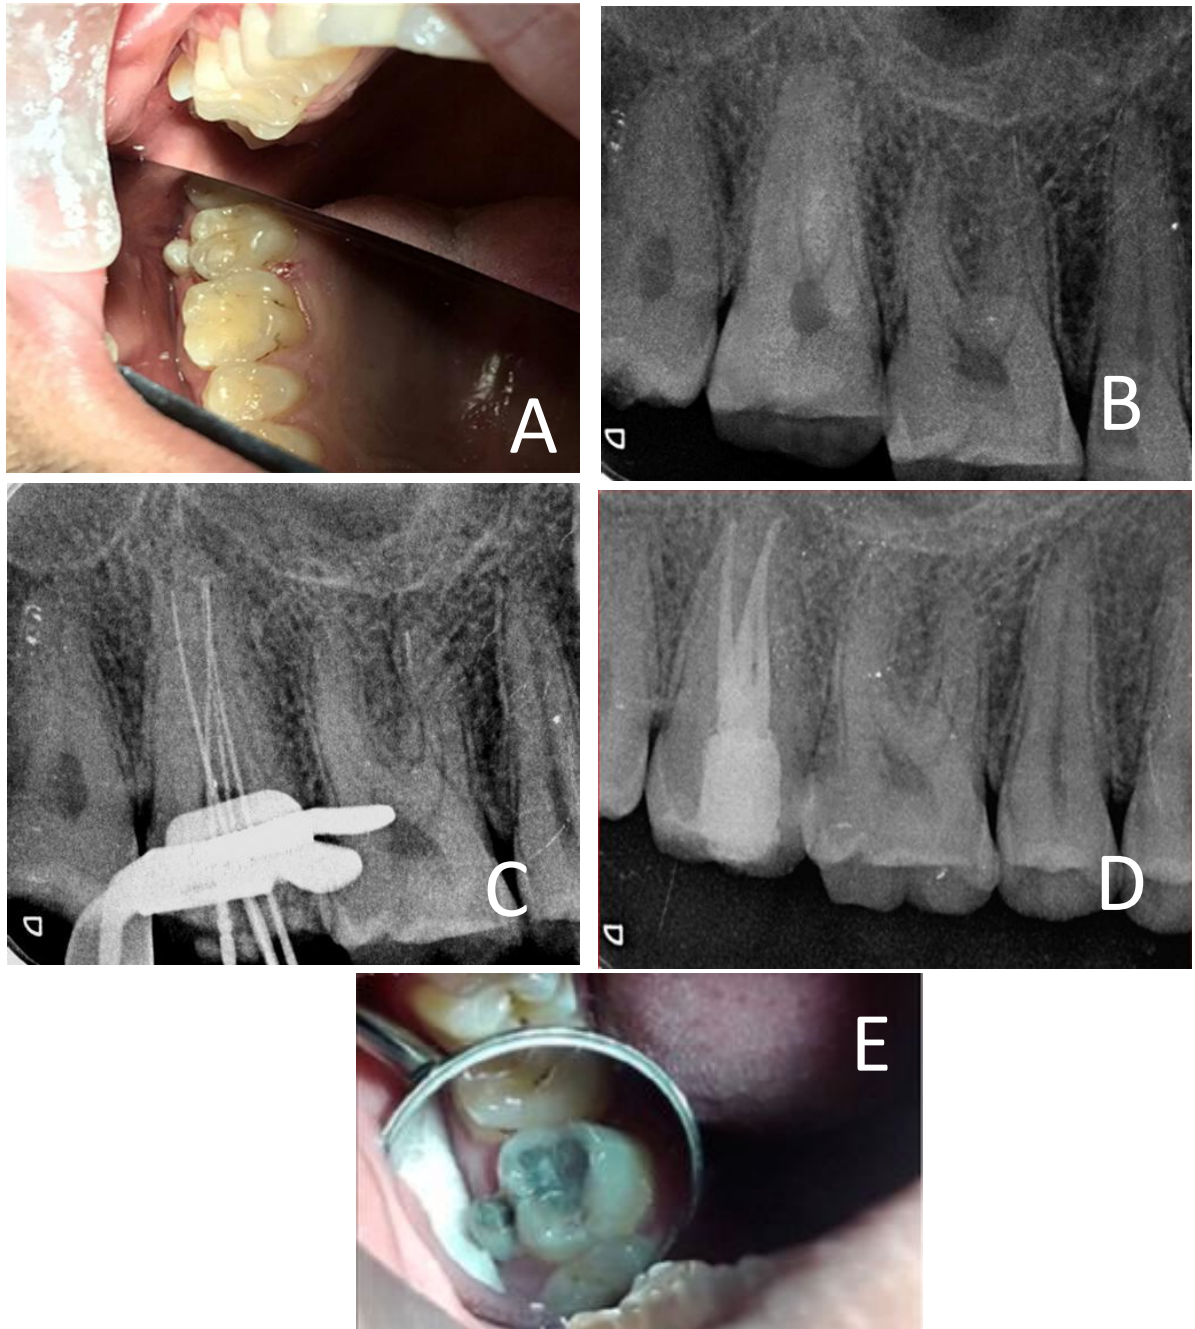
endodontic treatment of of the geminated maxillary second molar tooth using CBCT (A) Intraoral photograph of the tooth
